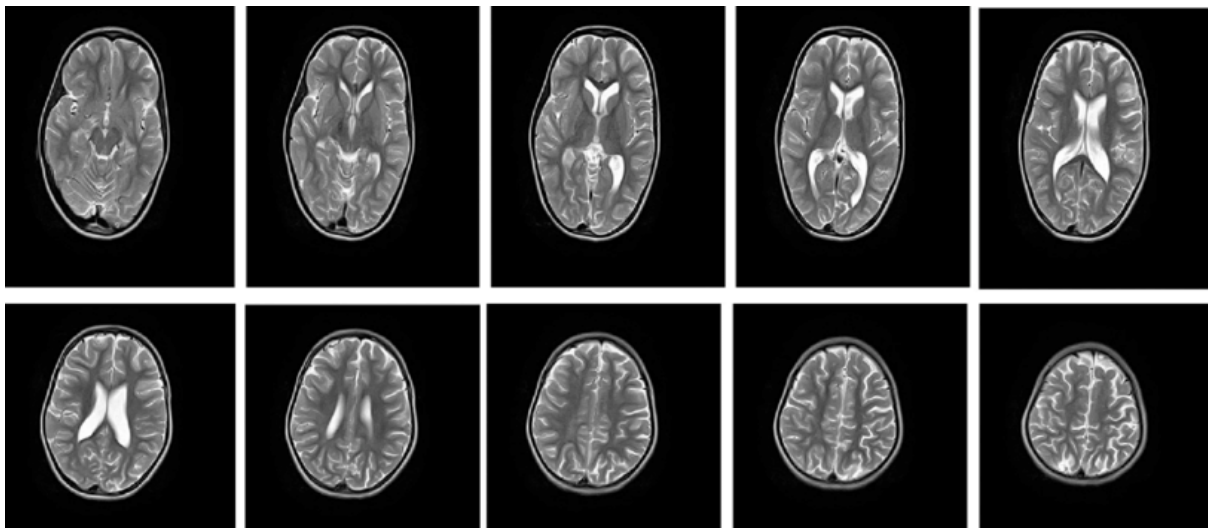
MRI brain showing normal findings, no abnormal density<sup>18</sup>
